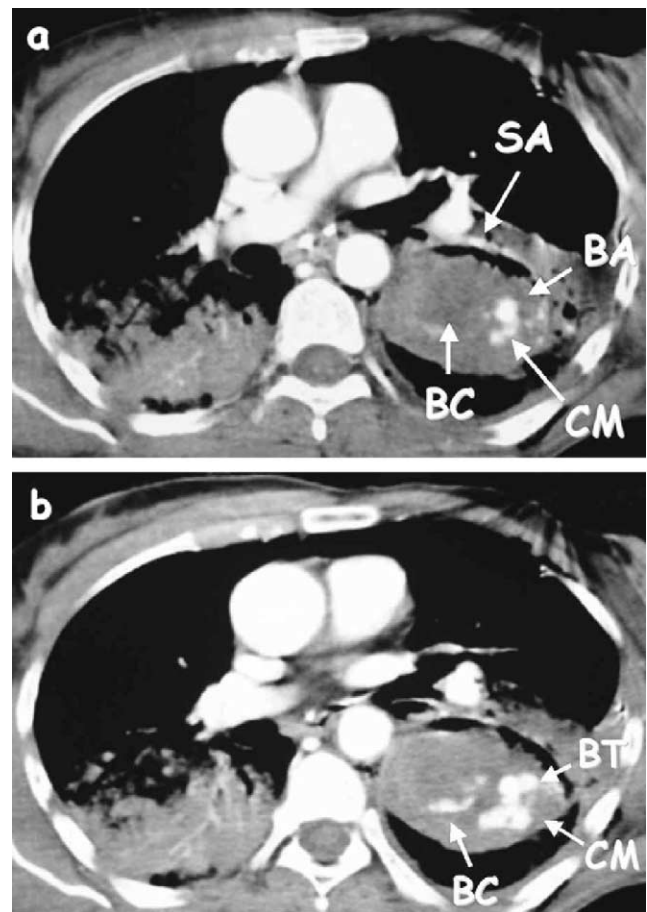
(a and b) Contrast enhanced CT scan showing a rupture of the left basal arterial trunk as the source of bleeding with secondary formation of a large (4×9 cm) intrapulmonary blood collection. Arrow SA: superior segmental artery of the left lower lobe. Arrow BA: basal arterial trunk. Arrow CM: extravasation of the contrast medium. Arrow BC: intrapulmonary blood collection. Arrow BT: branches of the basal arterial trunk.
